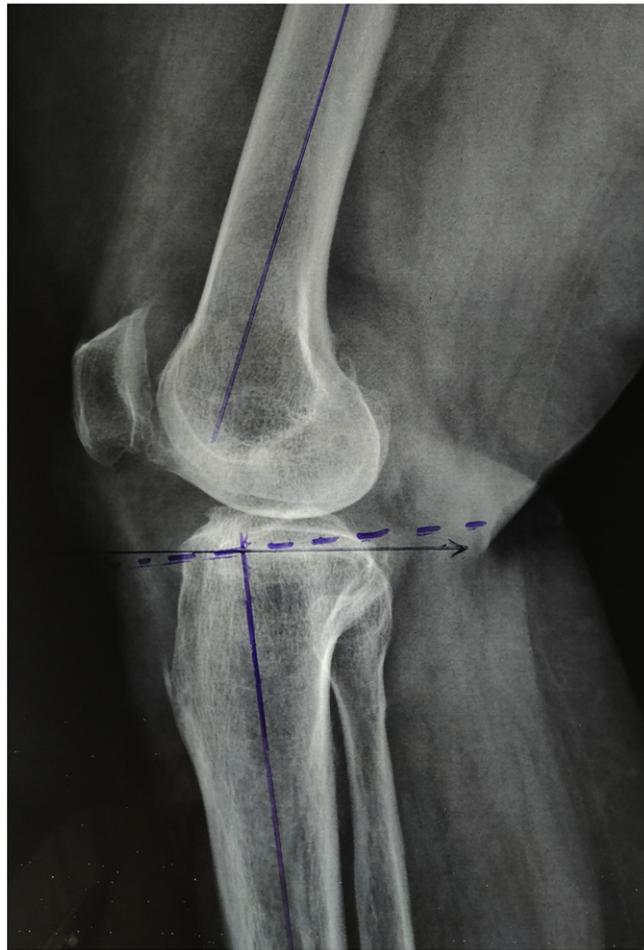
Pre-operative planning in lateral radiographs.
